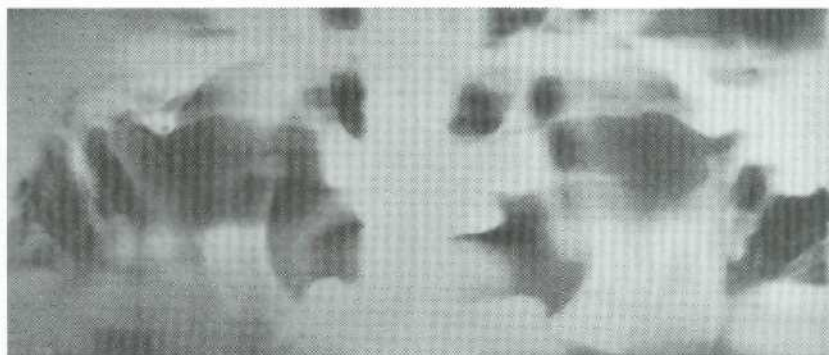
Modified panoramic view demonstrates normal anatomy of right condyle and degenerative changes of left condyle. This modified panoramic radiographic technique shows increased detail of posterior ramus and condyle area while eliminating the anterior mandible from radiographic image.
